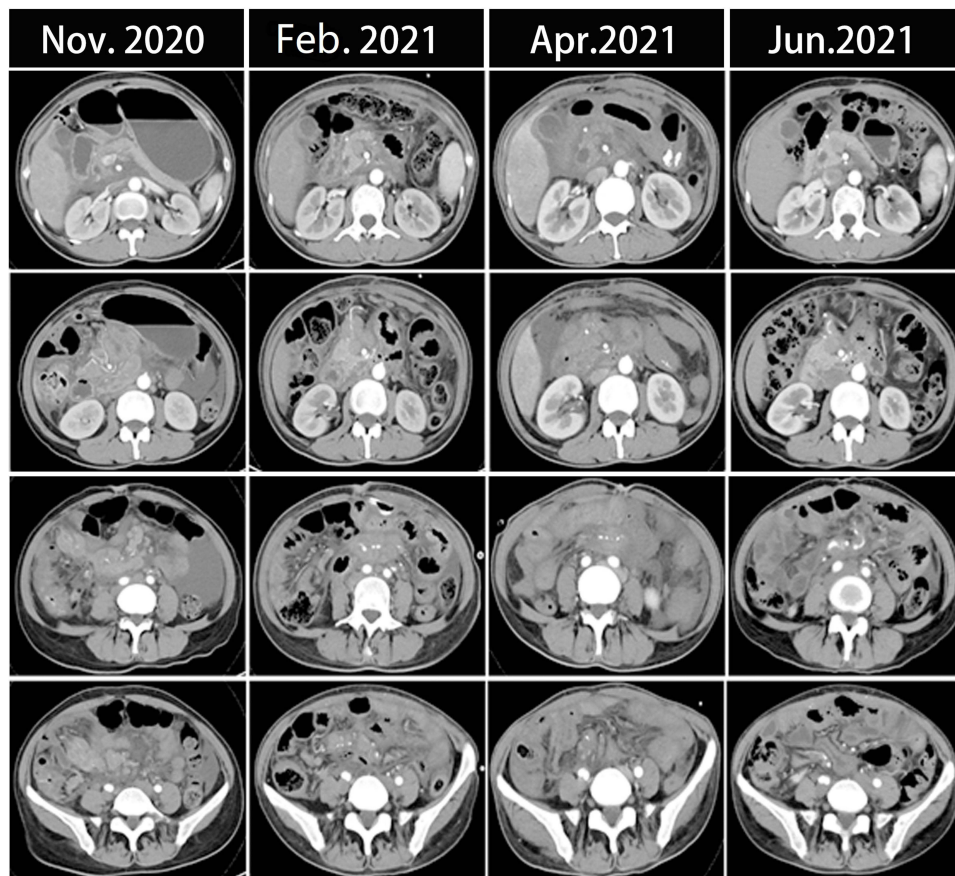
CT scans show the therapeutic response of patients following a series of treatment.
